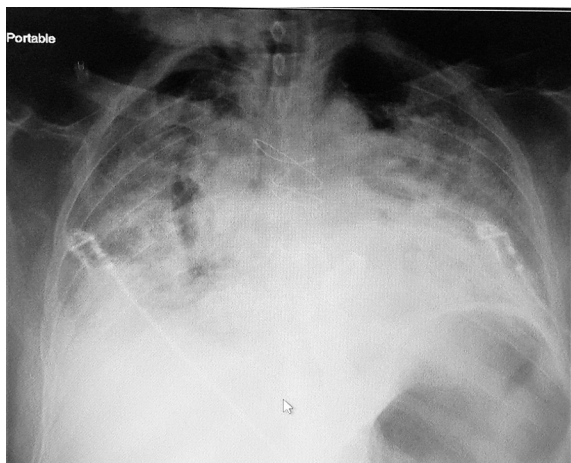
The chest x-ray showing diffuse bilateral alveolar infiltrates.
